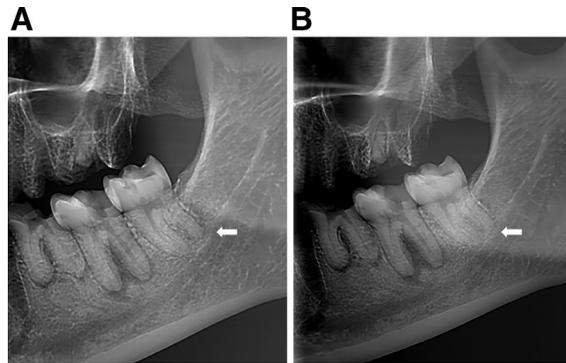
Cropped panoramic radiograph (A) and extraoral bitewing (B) of the same tooth showing a relationship of a distance 1 mm or less (A) and contact (B) between the root apex of the third molar and the mandibular canal (white arrow), respectively.
